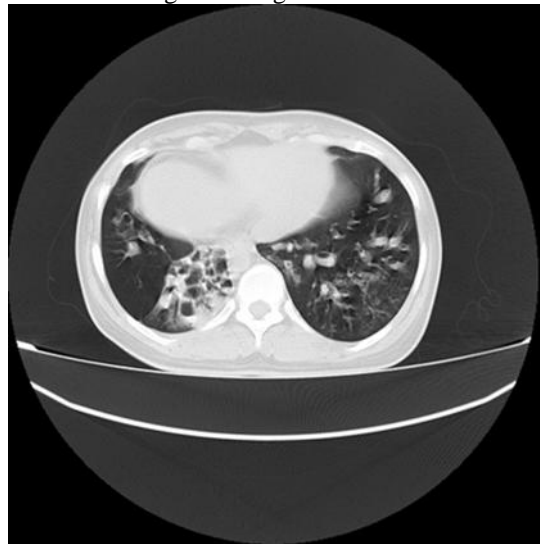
axial CT image showing with e/o ectatic changes with air fluid level in suprabasal, medial, posterior segment of left lower lobe,lingular lobe.
